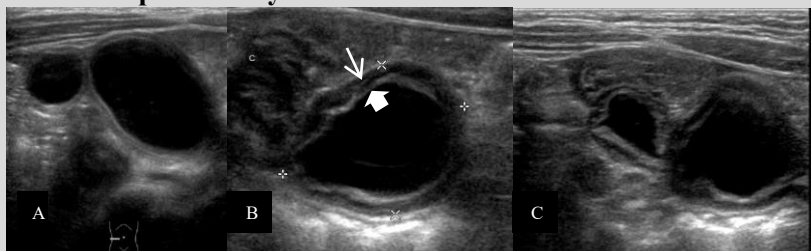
Post-natal abdominal ultrasound in a 4-month-old boy who had antenatally detected abdominal cysts, shows two cysts in the right lower abdomen.
